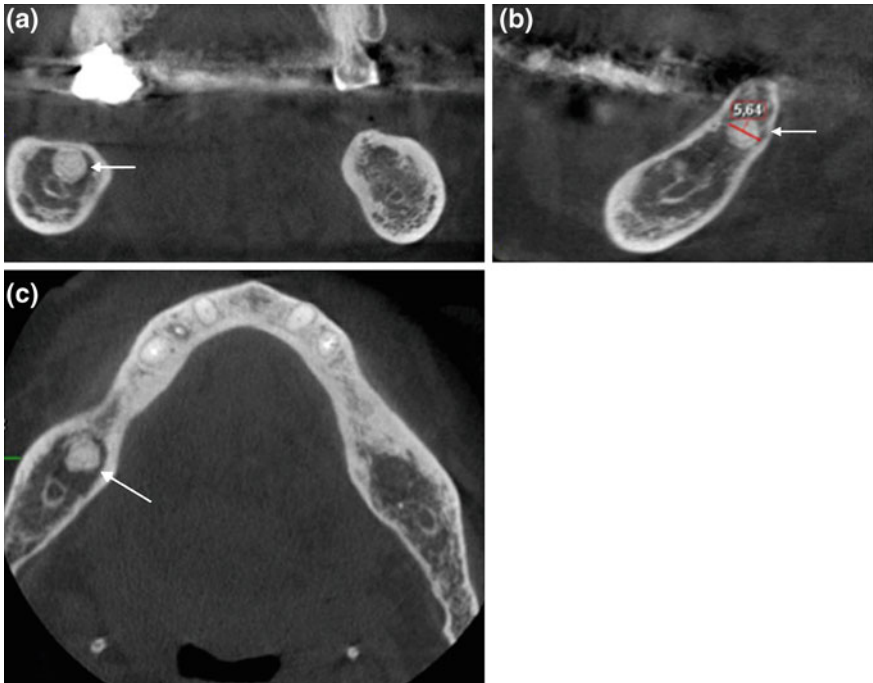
CBCT coronal (a), sagittal (b), and axial (c) scans showing in the region of right mandibular molars an well-defined dishomogeneous hyperdense lesion (arrows) with maximum diameter of 5,6 mm without alteration of cortical bone
